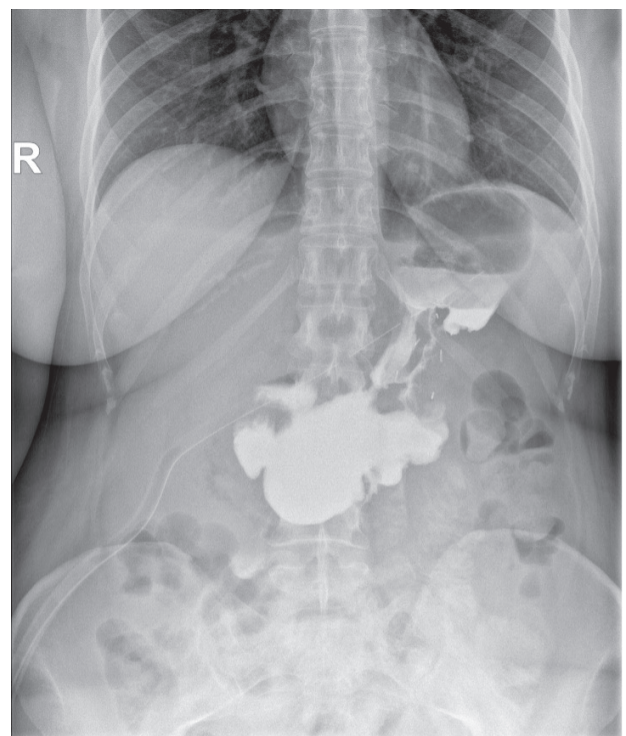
Postoperative gastrografin upper gastrointestinal radiography showing no leakage.
